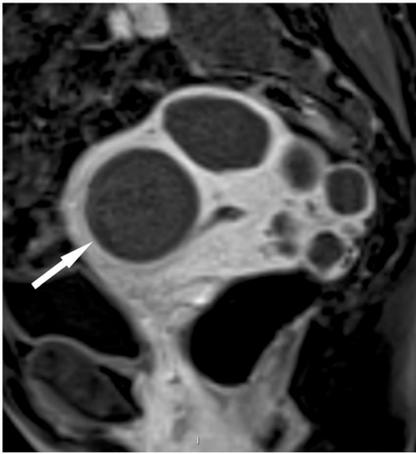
48-year-old woman who had uterine artery embolization (UAE) for symptomatic uterine leiomyomas. Gadolinium chelate-enhanced, T1-weighted, three-dimensional gradient echo (3D-VIBE®) sequence in the sagittal plane shows complete (100 %) devascularization of the dominant leiomyoma (*arrow*) on the 48-h post-UAE MR imaging
